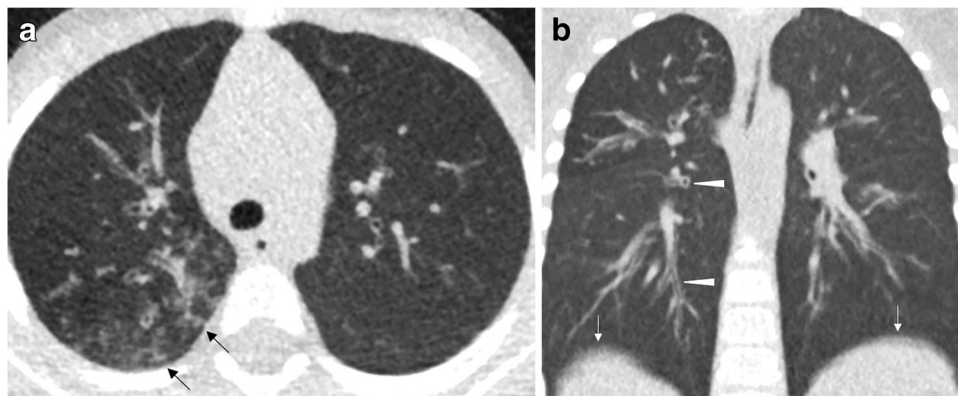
Photon-counting detector (PCD)-CT images in a 4-year-old girl with cystic fibrosis. a, b Axial (a) and coronal (b) images at 0.8-mm slice thickness demonstrate tree-in-bud opacities in the right lower lobe (*arrows* in a) as well as peribronchial thickening (*arrowheads* in b). Some breathing motion is seen at the diaphragms (*arrows* in b), and these images were obtained without sedation
